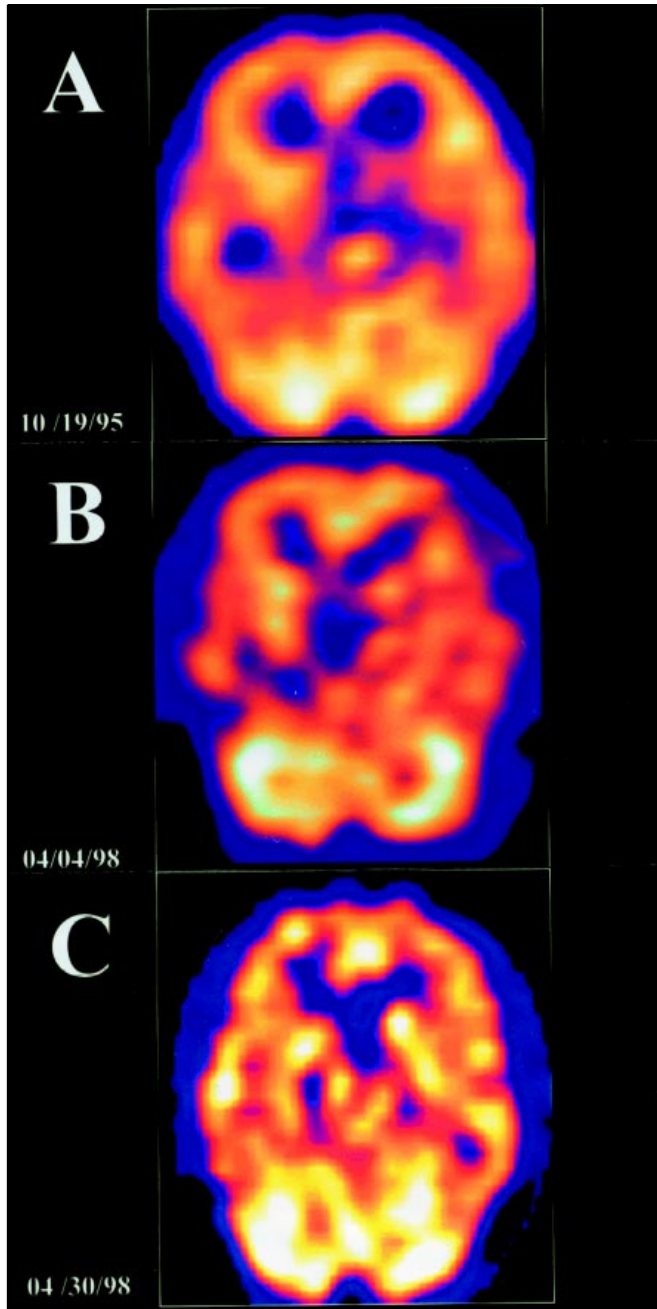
Brain SPECT imaging with ^{99m}Tc -HMPAO in a patient with Huntington's disease and severe choreiform movements. (A) Before treatment, there is marked hypoperfusion of the left basal ganglia. (B) After 2 years of treatment with haloperidol there is only slight improvement of the left basal ganglia perfusion. (C) After withdrawal of haloperidol and a 20-day trial with olanzapine there is marked improvement of left basal ganglia perfusion.
